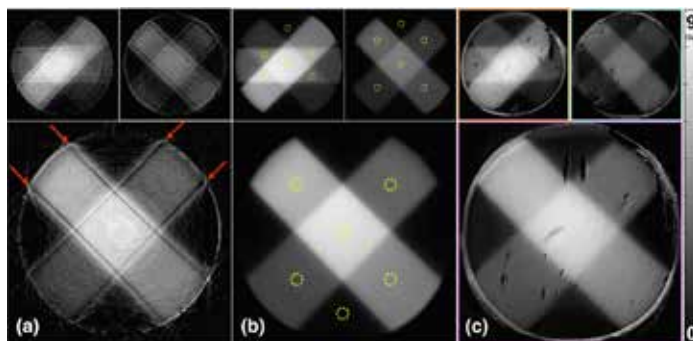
Dose images for two irradiation patterns – a star pattern and two dosages of a cross pattern – are shown in (a) optical CT reconstructions, (b) TPS-calculated dose distributions, and (c) DBBR scans. Circular ROIs, 5 mm in diameter and indicated in (b), were used for DBBR-to-TPS comparisons and DBBR calibration.
